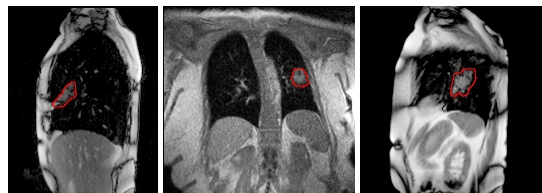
Example slices of the cine MR images (bSSFP and GRE) acquired with a Siemens Aera 1.5T. The in-plane resolution is 2mm isotropic and the slice thickness is 5mm. Manually delineated tumour contours are depicted in red.
